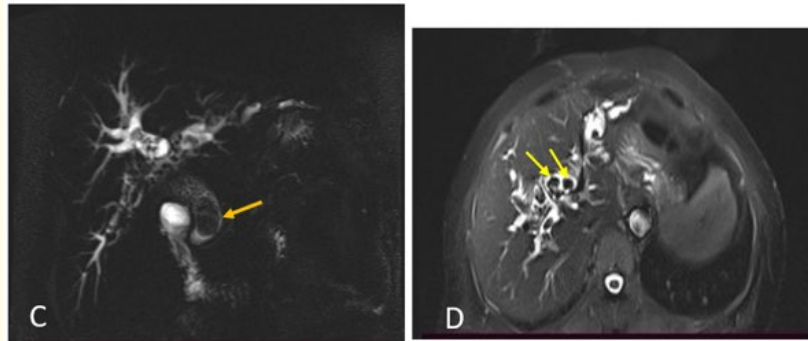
Axial section of a 3D MRCP (C), and a Bili-MRI in T2 HASTE STIR sequence (D), showing multiples gallstones in the dilated intra-hepatic bile ducts (yellow arrows), and an enlarged CBD above a large lithiasis (orange arrow).
